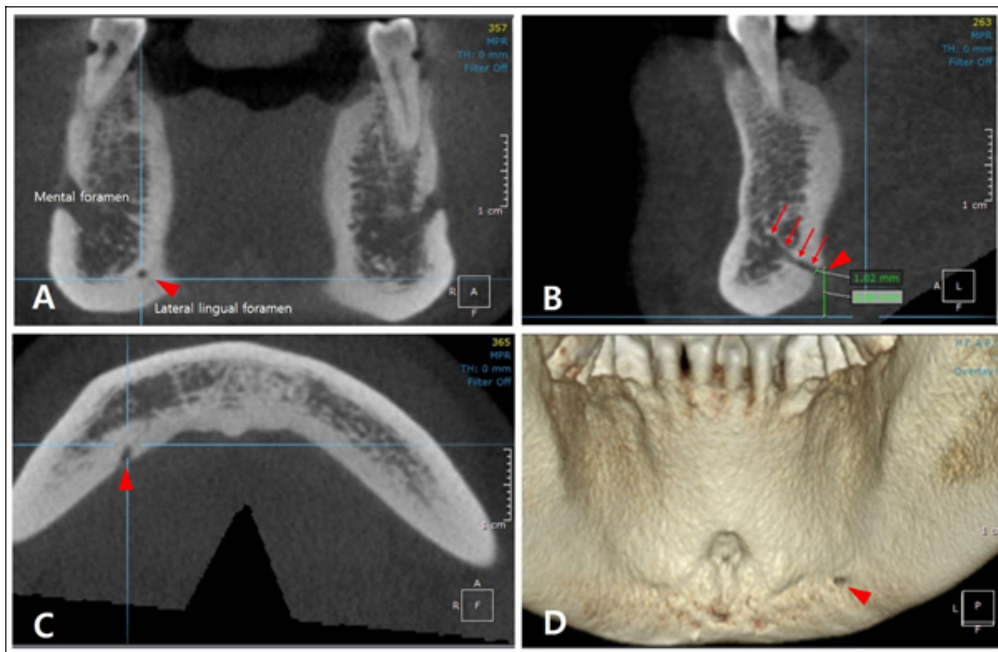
Cone beam computed tomography (CBCT) images of the lingual foramen and the lateral lingual foramen. A, Superior lingual foramen (arrowhead) located above the mental spine (dotted red line) in the sagittal plane. B and C, Lateral lingual foramen (arrowhead) in the sagittal and axial planes, respectively. The diameter of each foramen was measured at the point where the canal starts within the orifice of the foramen in the sagittal plane. The height to upper margin of each foramen and the bone height to alveolar crest of the mandible from the inferior border of the mandible were also measured. The lingual foramen was evaluated the direction based on the sagittal plane. And the lateral lingual foramen was evaluated the location related to the tooth position, the direction based on the sagittal and transverse planes, and whether the communication with the mandibular canal or the incisive canal.
